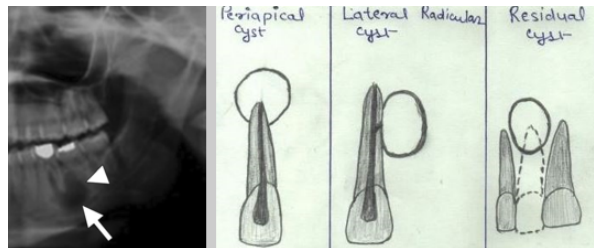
Right – Xray shows cystic lesion in relation to the root of the cyst.
